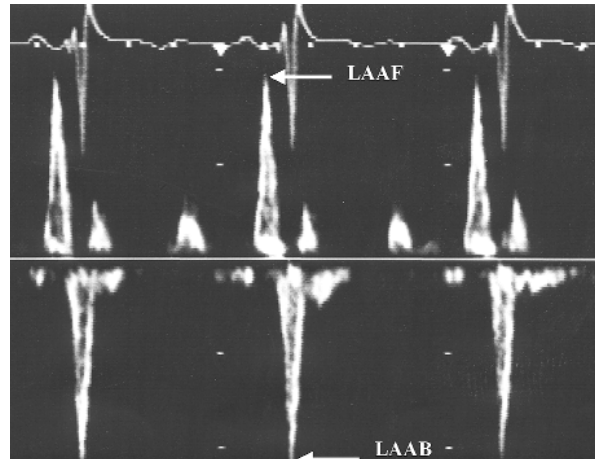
Doppler velocity flow in LAA during the sinus rhythm. The method of parameters calculation
